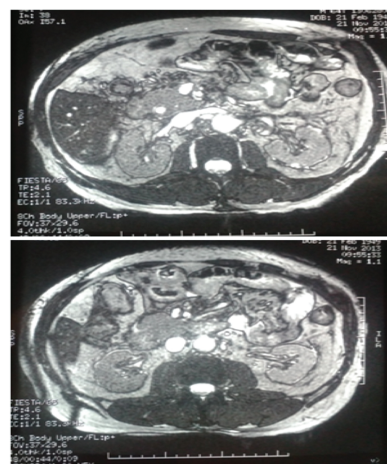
Right adrenal hyperplasia and left adrenal adenoma at abdominal MRI.
